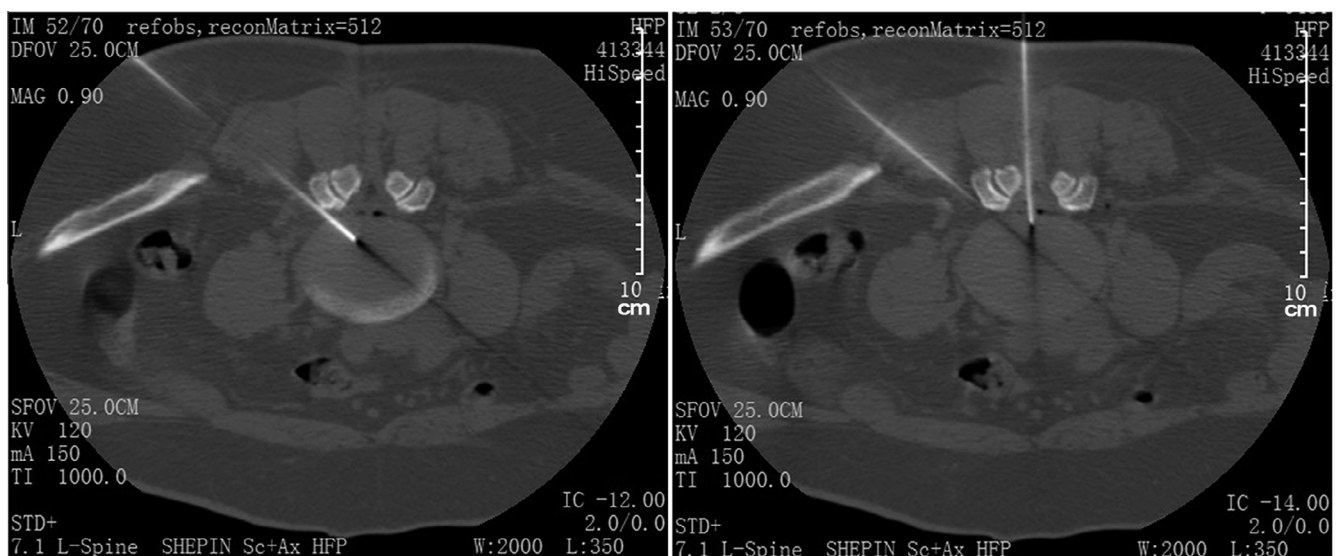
Axial CT scan with bone windows shows punctures from the medial and lateral edges of the left facet joint.
